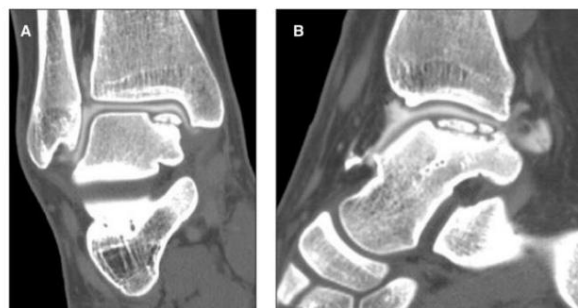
CT of the ankle with intra-articular contrast. We can assume that there is no cartilage tear despite the osteochondral lesion that is evident since the contrast does not leak below the lesion. Images obtained from the work of Bauer KL, & Polousky, JD (12)
